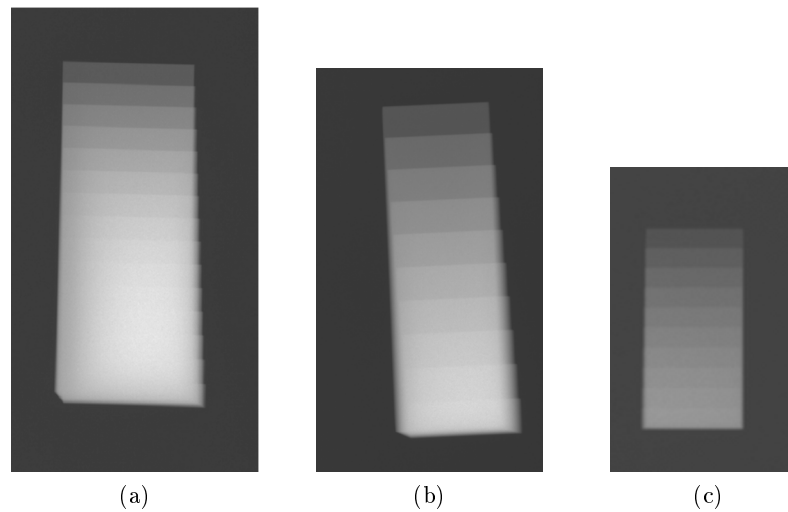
X-rays of the three wedges; a) fifteen 5 mm step, b) ten 5 mm step and c) ten 2 mm step.
